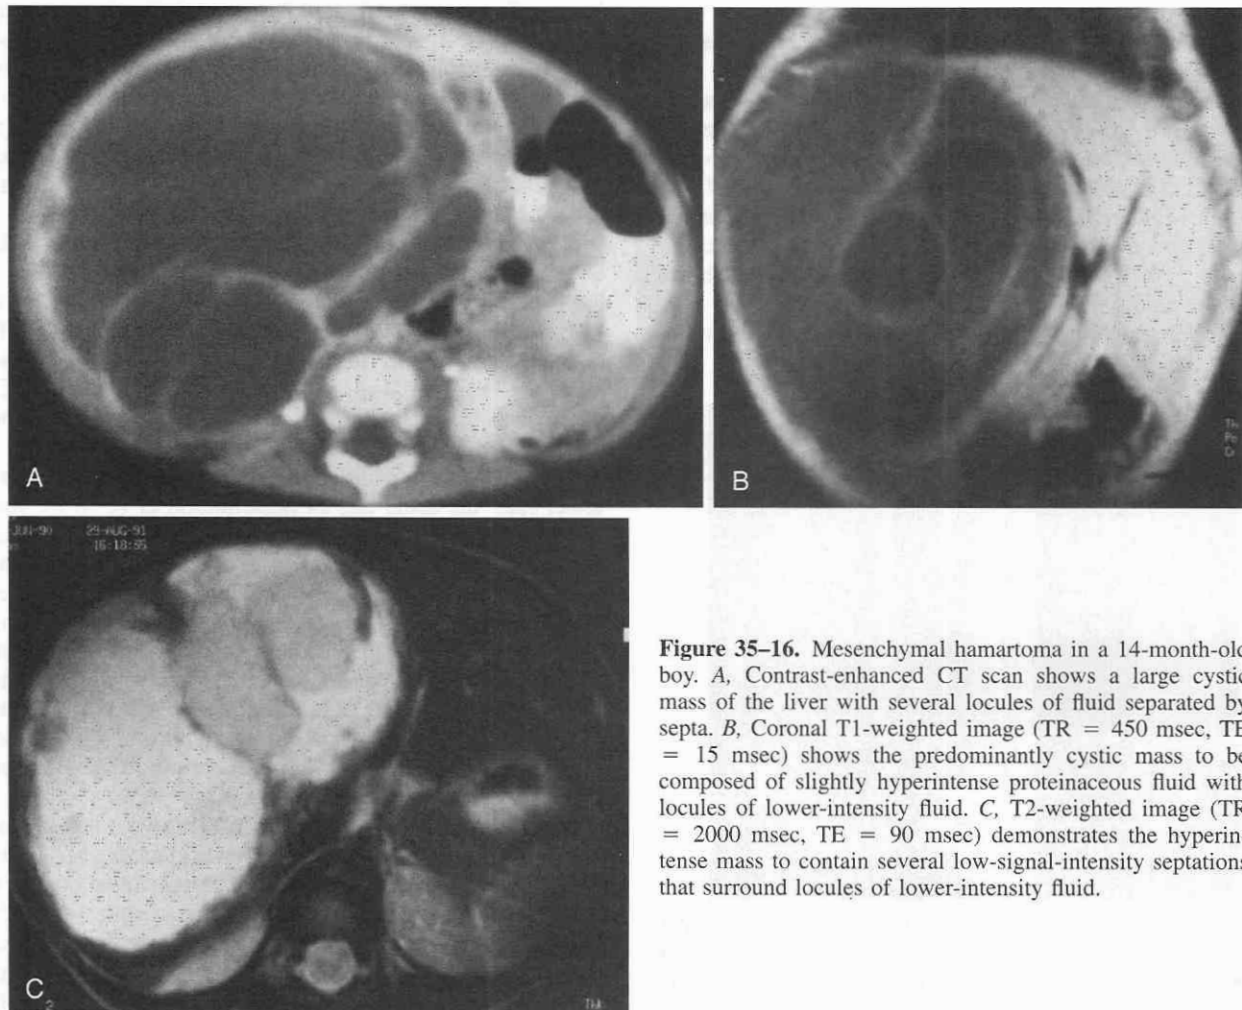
Mesenchymal hamartoma in a 14-month-old boy. A, Contrast-enhanced CT scan shows a large cystic mass of the liver with several locules of fluid separated by septa. B, Coronal T1-weighted image (TR = 450 msec, TE = 15 msec) shows the predominantly cystic mass to be composed of slightly hyperintense proteinaceous fluid with locules of lower-intensity fluid. C, T2-weighted image (TR = 2000 msec, TE = 90 msec) demonstrates the hyperintense mass to contain several low-signal-intensity septations that surround locules of lower-intensity fluid.
